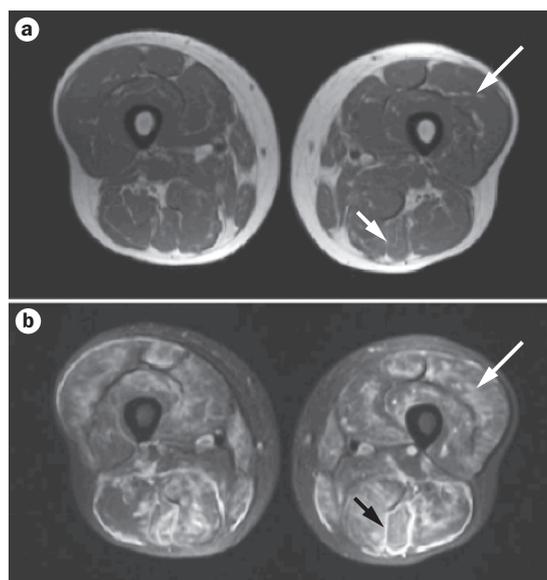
Thigh MRI from a patient with dermatomyositis. a | In T1-weighted images, fat is bright and muscle is dark. b | In short tau inversion recovery sequences, normal muscle is dark and inflamed muscle is bright. Long arrows indicate the inflamed left vastus lateralis muscle. Short arrows highlight the left biceps femoris muscle; the bright rim around this muscle is consistent with fascial inflammation.
